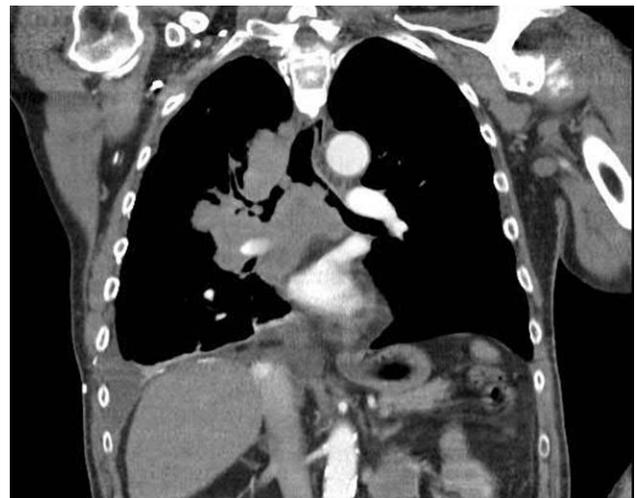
Bilateral Mainstem Bronchial Obstruction Shown on Coronal Computed Tomography.
